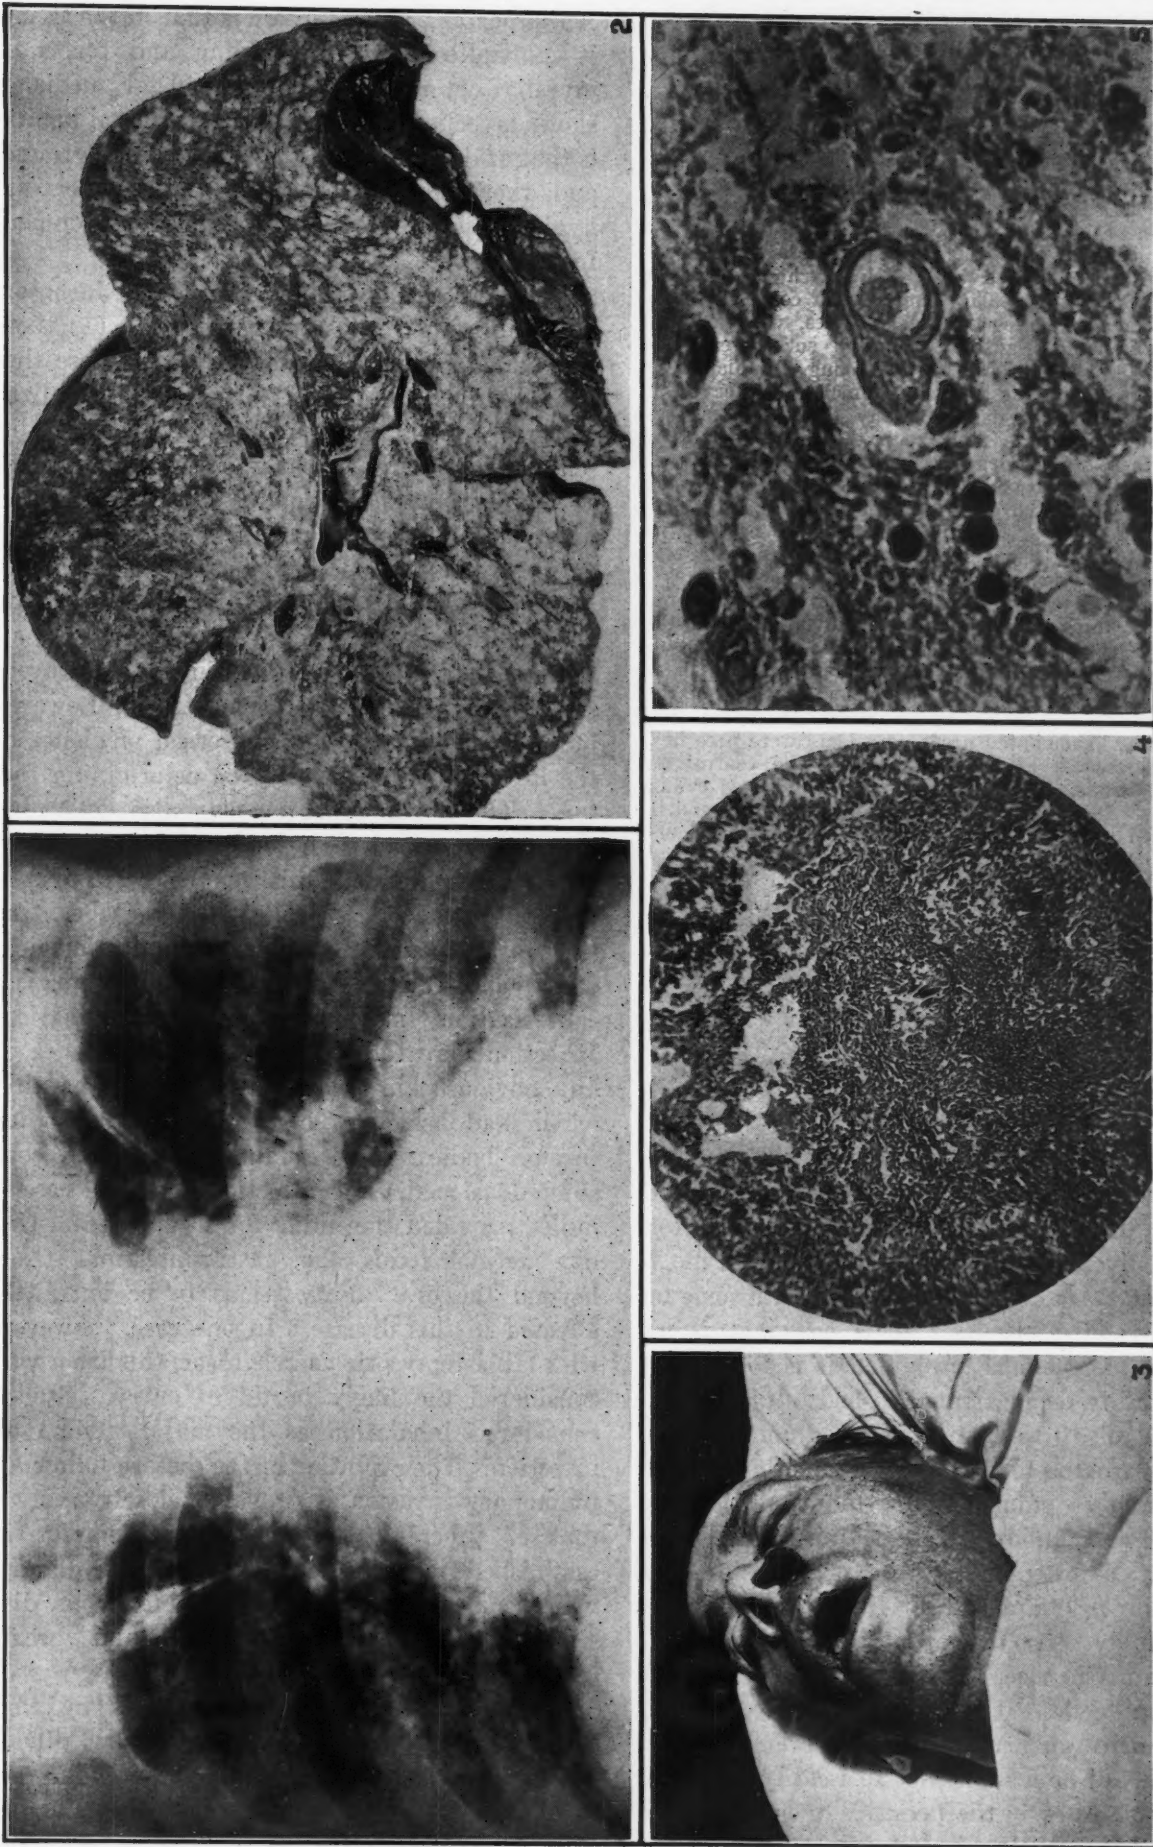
X-ray of chest. Distribution of lesions suggest miliary tuberculosis, but differ in the hilar distribution, and in being coarser, larger and more dense. Fig. 2.—Blastomycosis of lung. Gross appearance showing miliary distribution of lesions. Fig. 3.—Mass under ala nasi. Fig. 4.—Blastomycosis of lung (x 50) showing a large area of caseous necrosis and tubercle formation. Fig. 5.—Blastomycosis of spinal cord, showing an organism in the budding phase.
